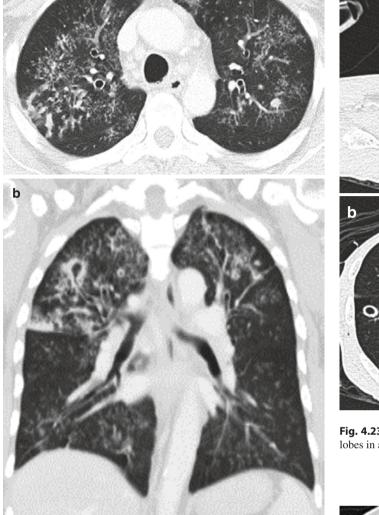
(a, b) Axial CT images show endobronchial tuberculosis with centrilobular nodules and cavity
